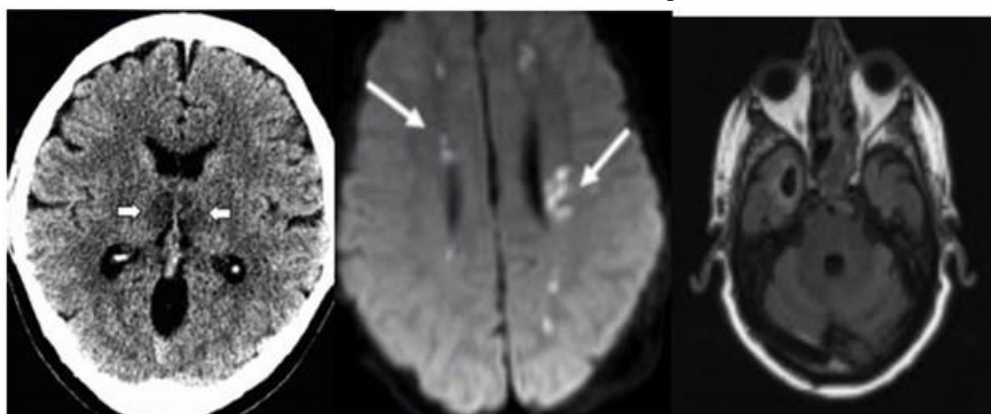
MRI Brain showing hyperintense lesions in the subcortical white matter, thalamus and basal ganglia
